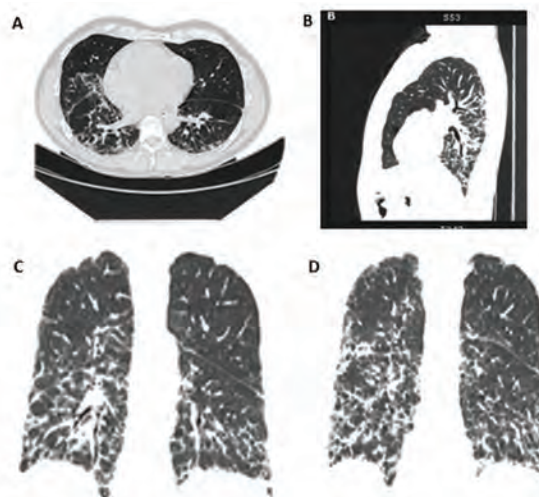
Thorax CT scan of the studied patient showing reticular interstitial pattern associated with ground-glass opacification predominantly in the lower lobes and more marked in the right lung than the left. A: Axial view B. Sagittal view C. and D: Coronal views.
